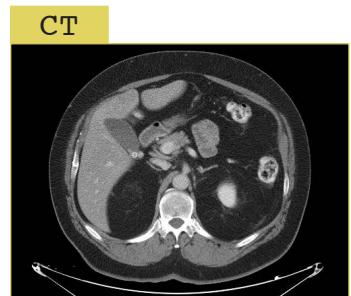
Normal CT of abdomen with contrast. Even in retrospect, no abnormality could be found in liver.
